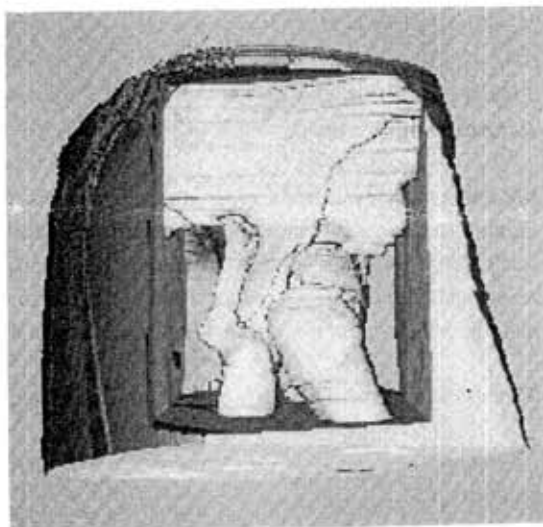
Combined presentation of surface and cross-sectional information of a fractured pelvis in CT. (Material: 77 slices, 256x256)
